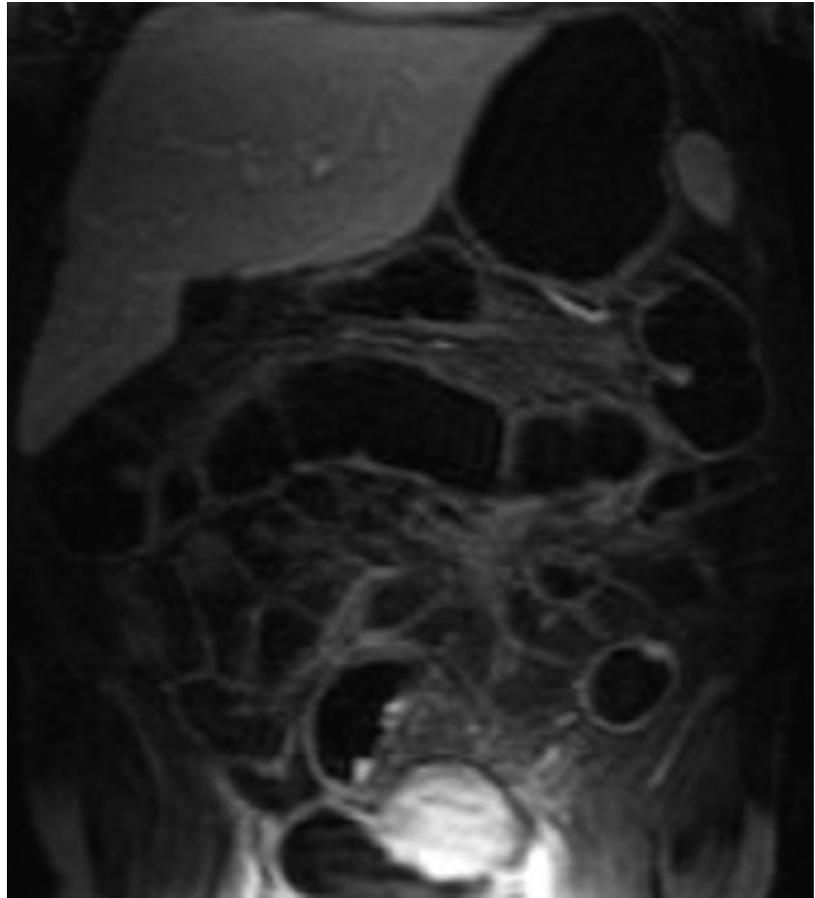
Additional rectal enema in hydro-MRI of a 39-year-old male patient with known Crohn’s disease. Multiple hyperplastic small polyps can be detected in the descending and sigmoid colon (arrows).
